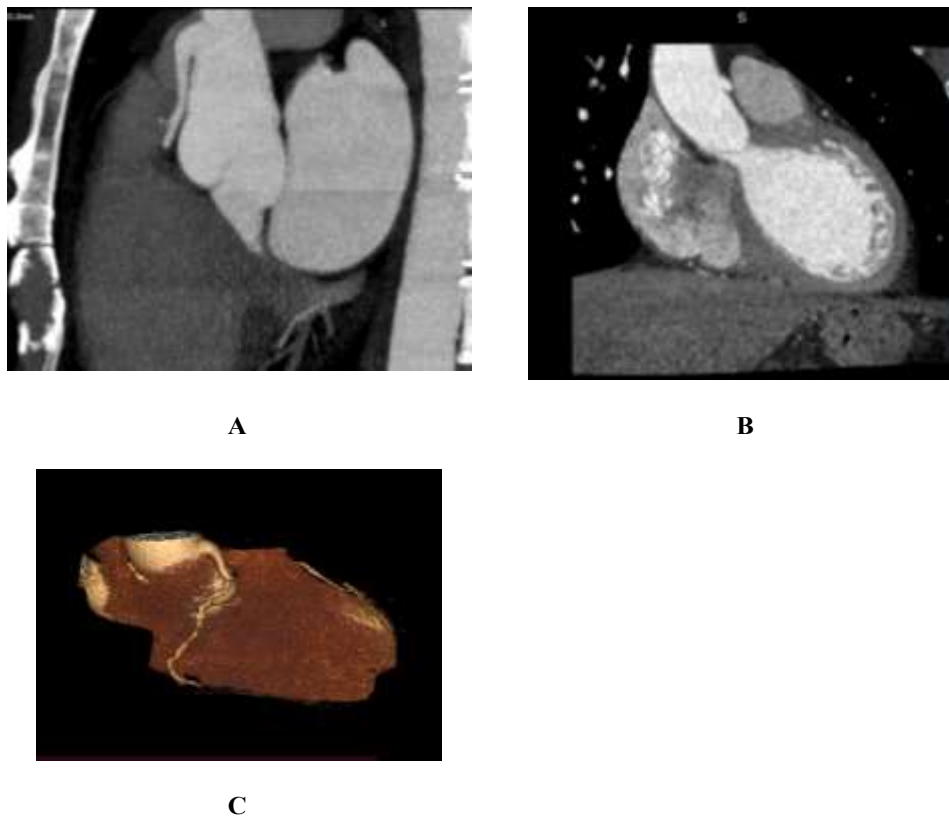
50 years old male patient presented with frequent attacks of chest pain increased at stress. *A.* Sagittal MIP image, *B.* coronal oblique image, *C.* VR 3d image of CT CA showing high origin of the RCA from the ascending aorta a distance above the sino-tubular junction.
